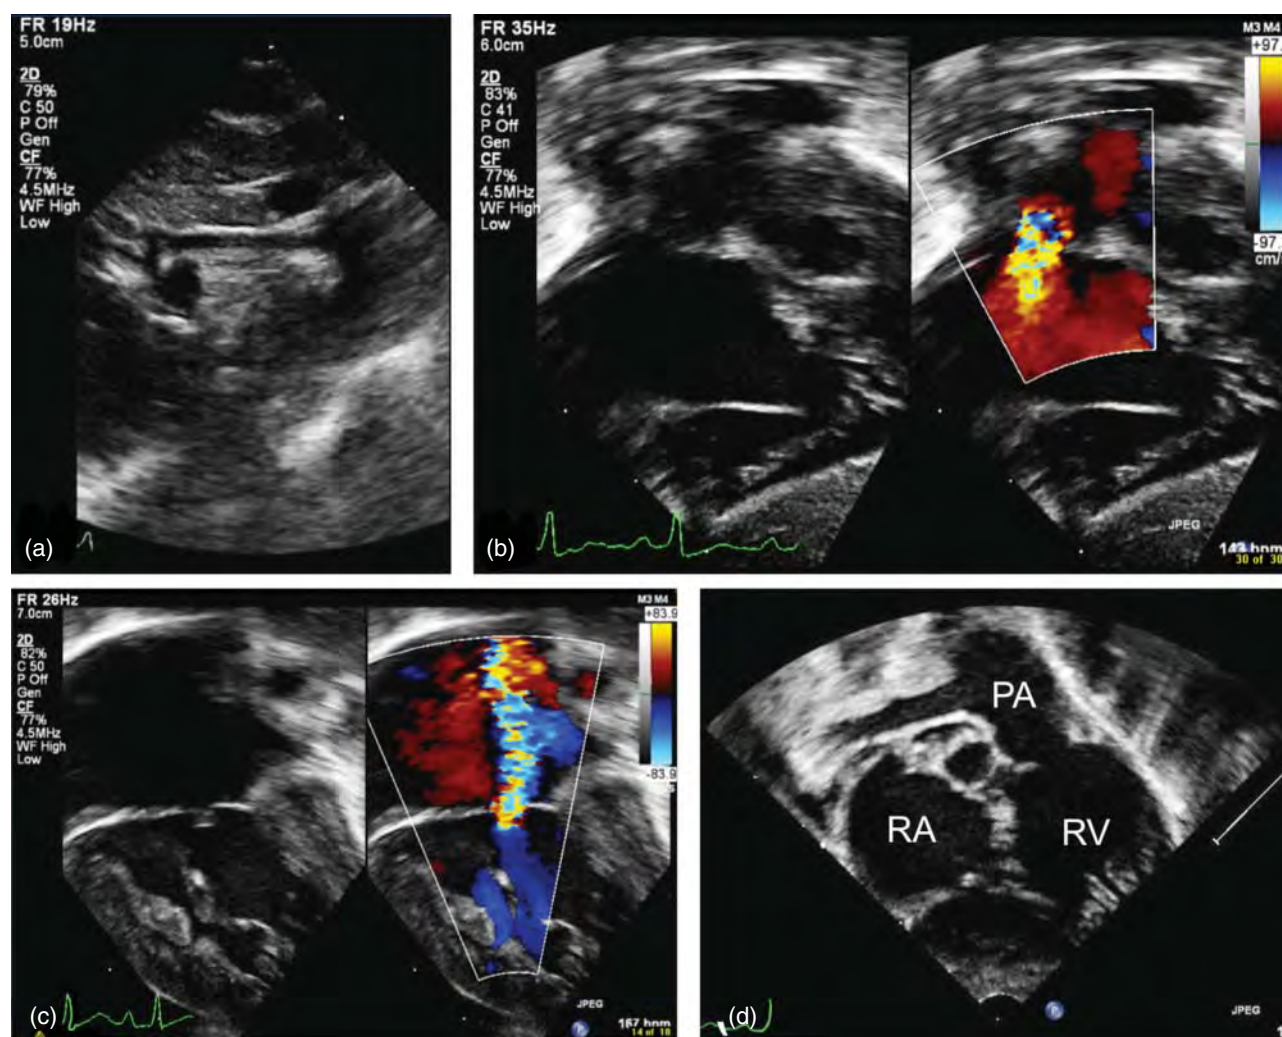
Echocardiographic assessment of HLHS depicting: (a) diminutive ascending aorta; (b) turbulent flow through a restrictive atrial communication; (c) severe tricuspid regurgitation; (d) subcostal oblique view of the right ventricle. PA, pulmonary artery; RA, right atrium; RV, right ventricle.
